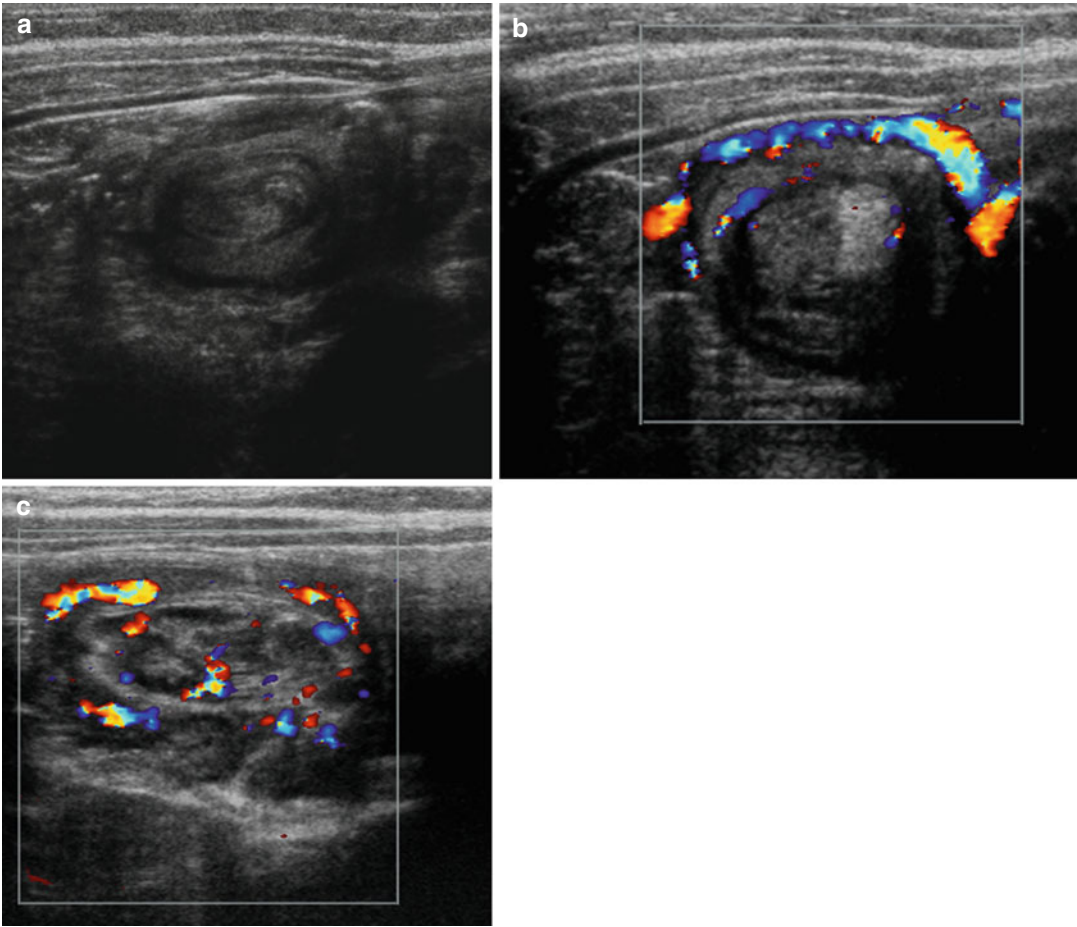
(a–c) Ultrasound B-mode and color Doppler scans in an infant with intestinal intussusception show the typical aspect “double-ring” sign in the wall of the perfused loop
